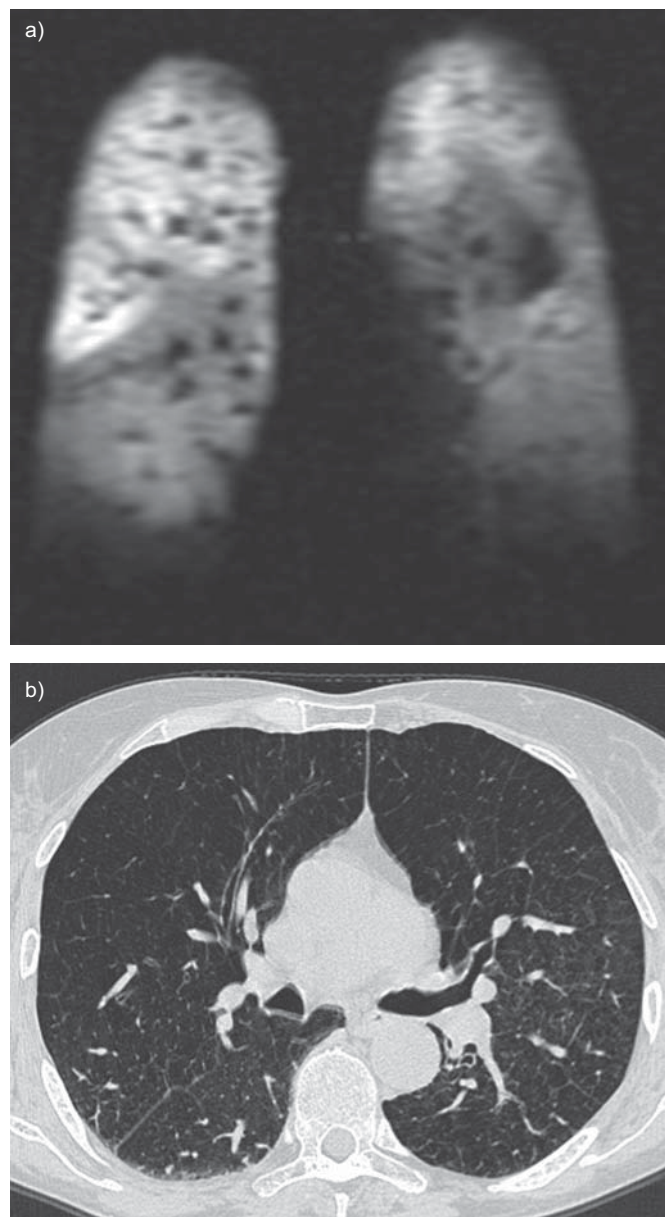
69-yr-old healthy male subject with normal lung function (forced expiratory volume in 1 s 88%). a) Hyperpolarised  $^3\text{He}$  magnetic resonance imaging grade mild (20% nonventilated lung) and b) high-resolution computed tomography grade mild (15% diseased lung).
